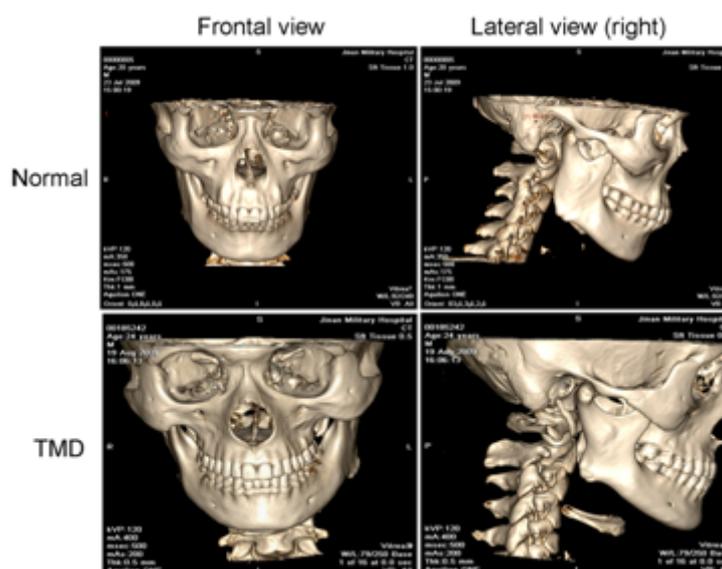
CT images in an occlusive position: condylar processes were located within the glenoid fossa in healthy subjects and the TMD patient. The dislocation of the front teeth was 0.2cm in the TMD patient.
